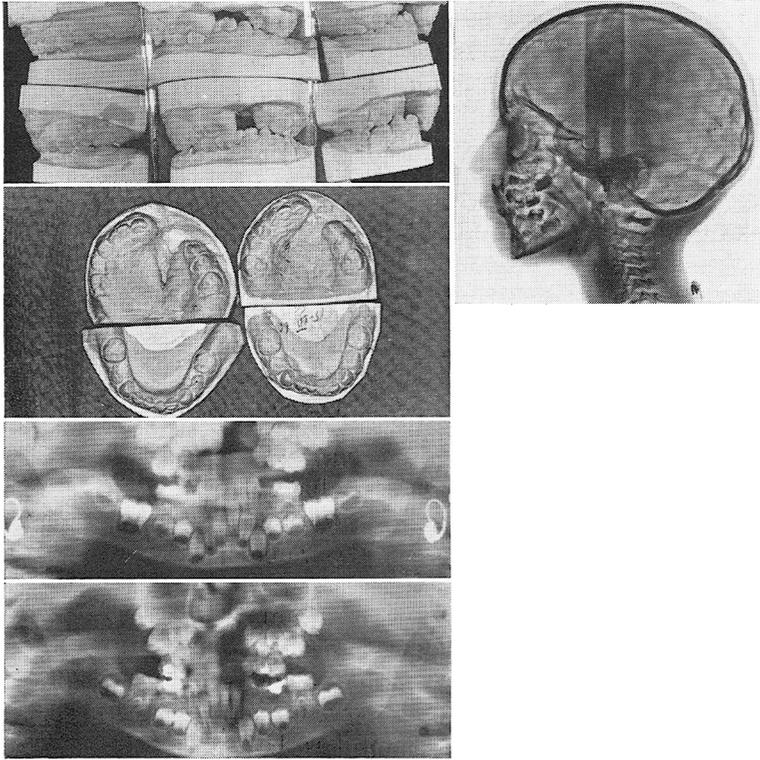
Unilateral left cleft lip and palate. The width of the maxilla is revealed by a rotation of the right side of the maxilla outward. The telerradiography performed at the beginning of the orthodontic treatment does not reveal a maxillary underdevelopment, but only a deep bite of the mandible in the second class, which causes, further, an asymmetry of the mandibular arch. By means of the panoramic radiographies performed during the controls, it was possible to study the development of the dentition, particularly at the margin of the cleft, which is always present, despite the sagittal development of the maxilla.
